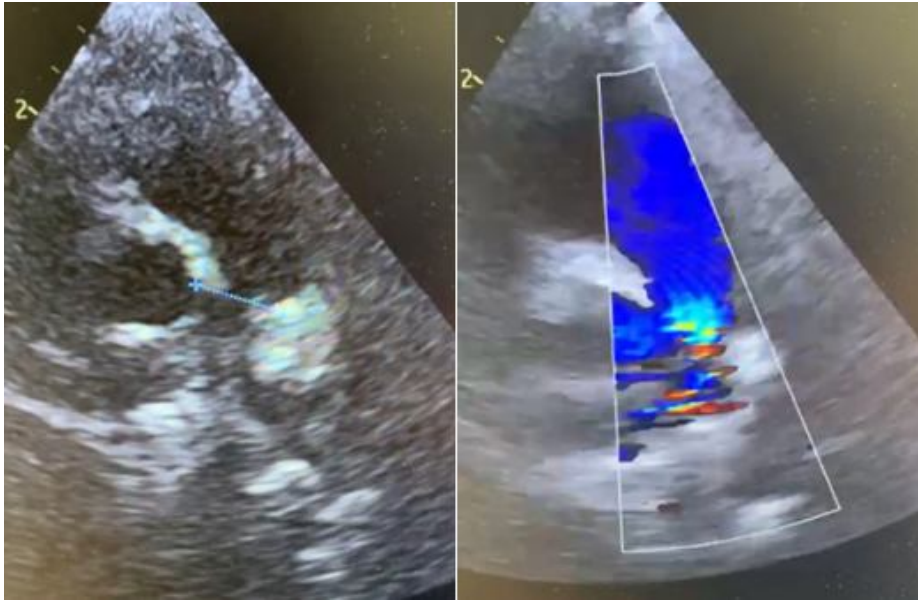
Right parasternal short axis view at the pulmonic valve level showing the increased velocity of flow was associated with the stenosis, which was not apparent at the level of the pulmonic valve.
